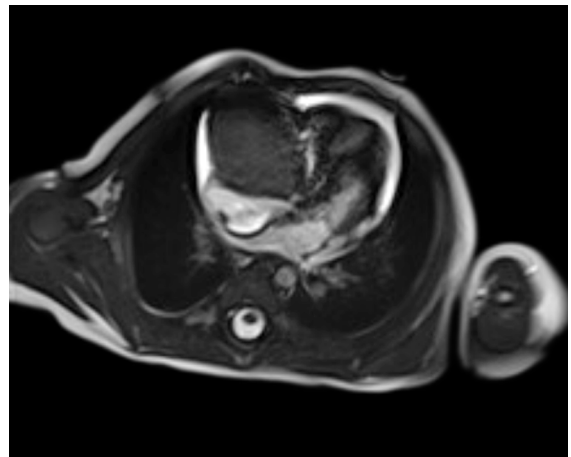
Preoperative magnetic resonance imaging sequence.
